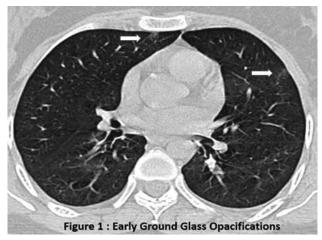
HRCT Axial image showing early ground glass opacifications
